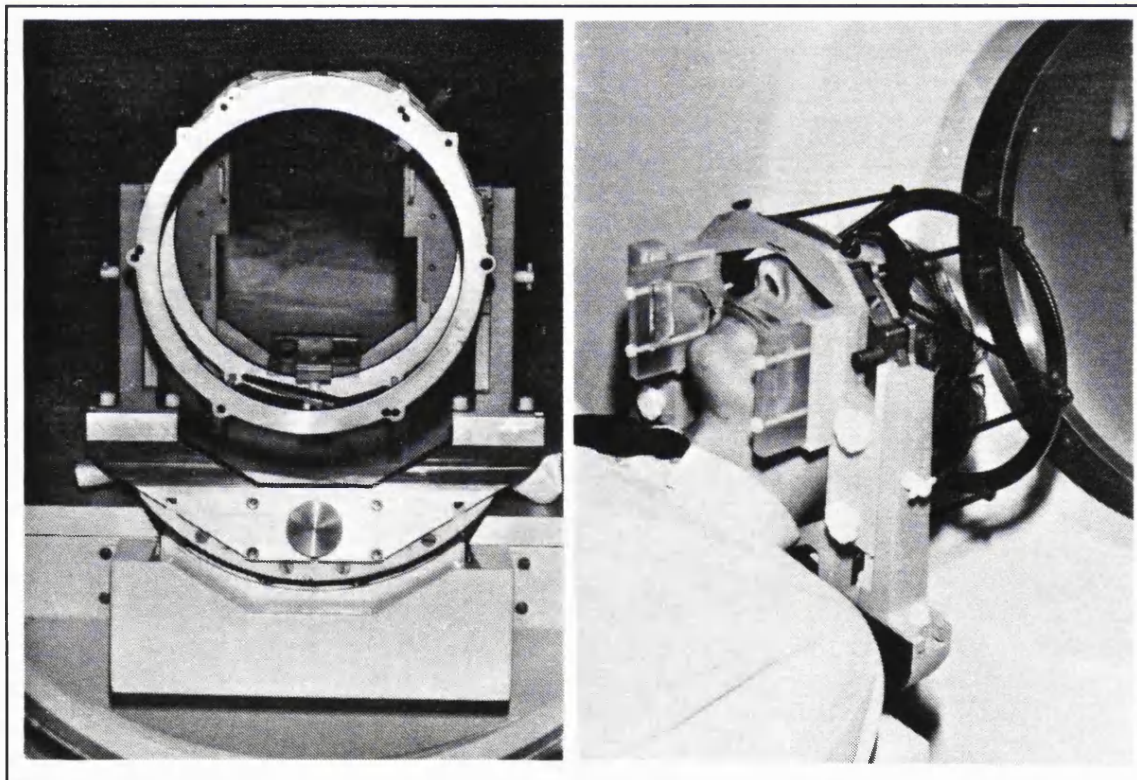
Relocatable frame with BRW system fixed to CT Scanner couch via Interface bracket
